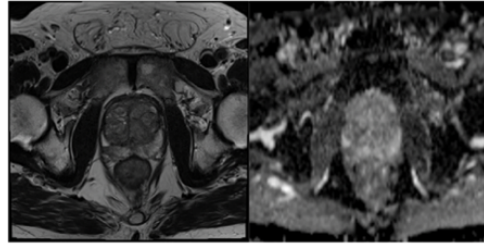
shows representative examples of negative MRI (T2WI and ADC) scans with positive and negative biopsy results. The proposed model can achieve a high averaged accuracy of 1.0 and 0.79, calculated by the total number of the correct prediction / the total number of the prediction with the 100 iterative random-split 10-fold cross-validations.
